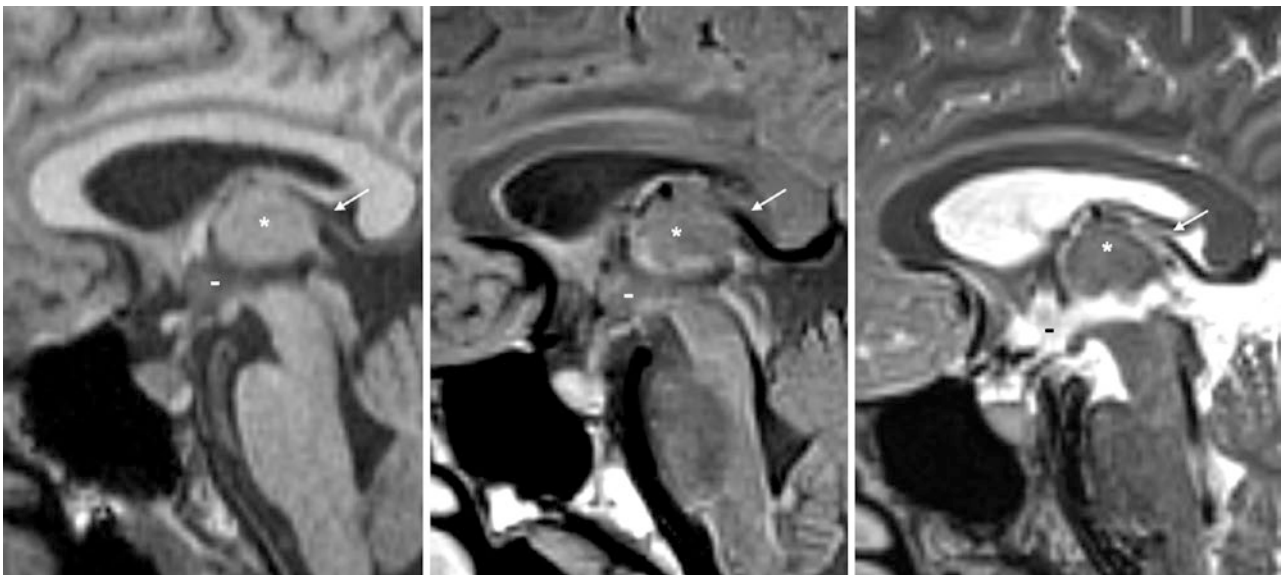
A 47 year old with a 3T MRI performed as part of a research study, which demonstrated a pseudomass of the massa intermedia (+) on a midline sagittal T1WI (left), T2WI (middle), and FLAIR
